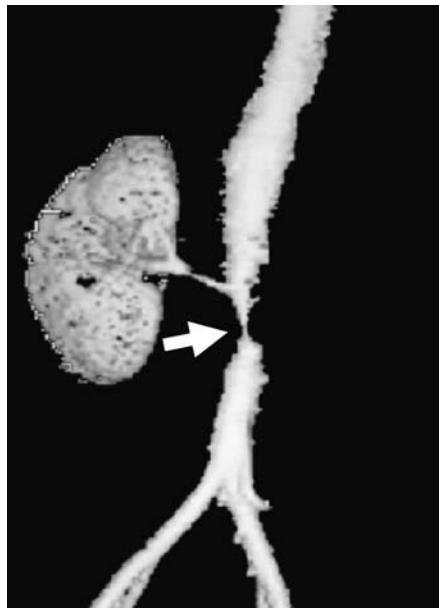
Left panel: magnetic resonance imaging (MRI) shaded-surface reconstruction showed aortic stenosis at the renal level (arrow) and occlusion of the left renal artery. Right panel: axial delayed enhancement in the abdominal aorta wall at the infra renal level associated with stenosis (arrow).
